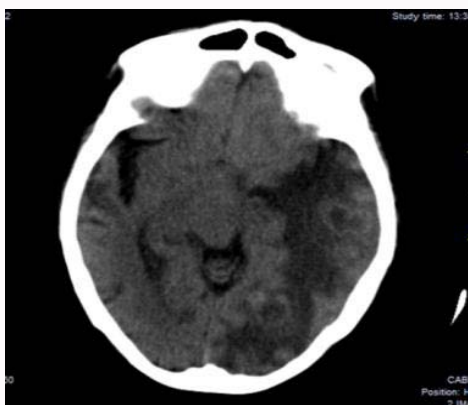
Cerebral CT showing multiple ring-enhancing lesions with perifocal oedema and mass effect on the midline structures in the left hemisphere.
